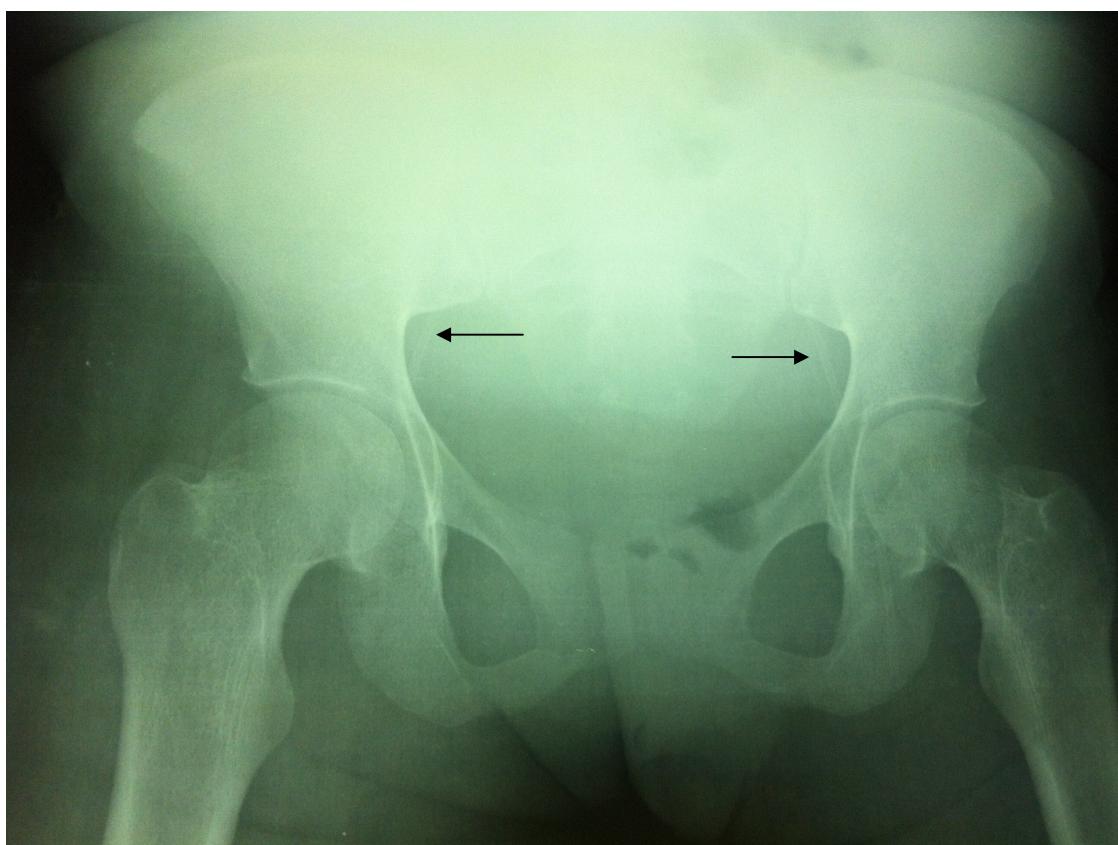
Plain radiograph of the pelvis, arrows showing the catheters
